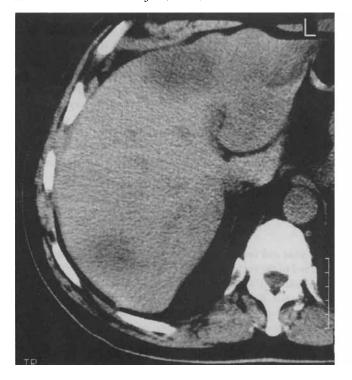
Case 4. Pretreatment unenhanced computed tomography scan of the liver. Between the liver metastases of low density, there is homogeneous liver tissue of normal attenuation.
